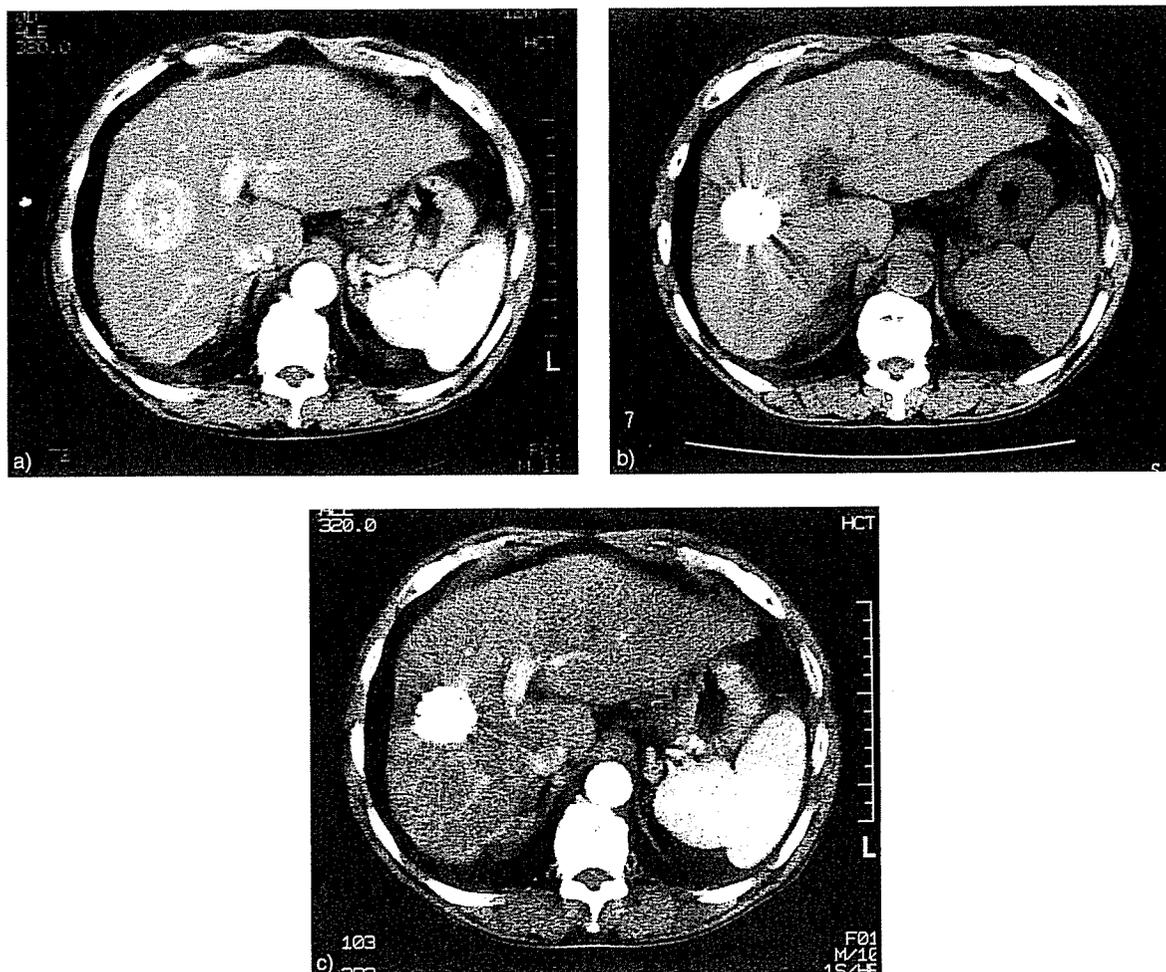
(a) CT scan before SM-11355 injection showed a hyperenhancing tumor in the right lobe of the liver; (b) CT scan which was performed 3 months after the second treatment showed dense accumulation of lipiodol throughout the whole tumor; (c) CT scan which was carried out 5 months after the second treatment showed maintenance of the lipiodol accumulation.
